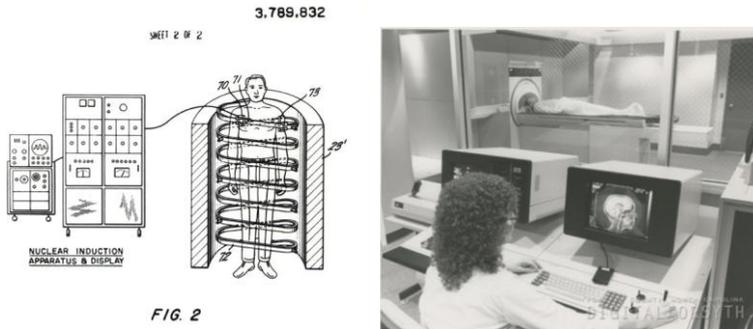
a) Prototype of the Indomitable included in the patent, (b) One of the first MRI commercial scanners (1983)
